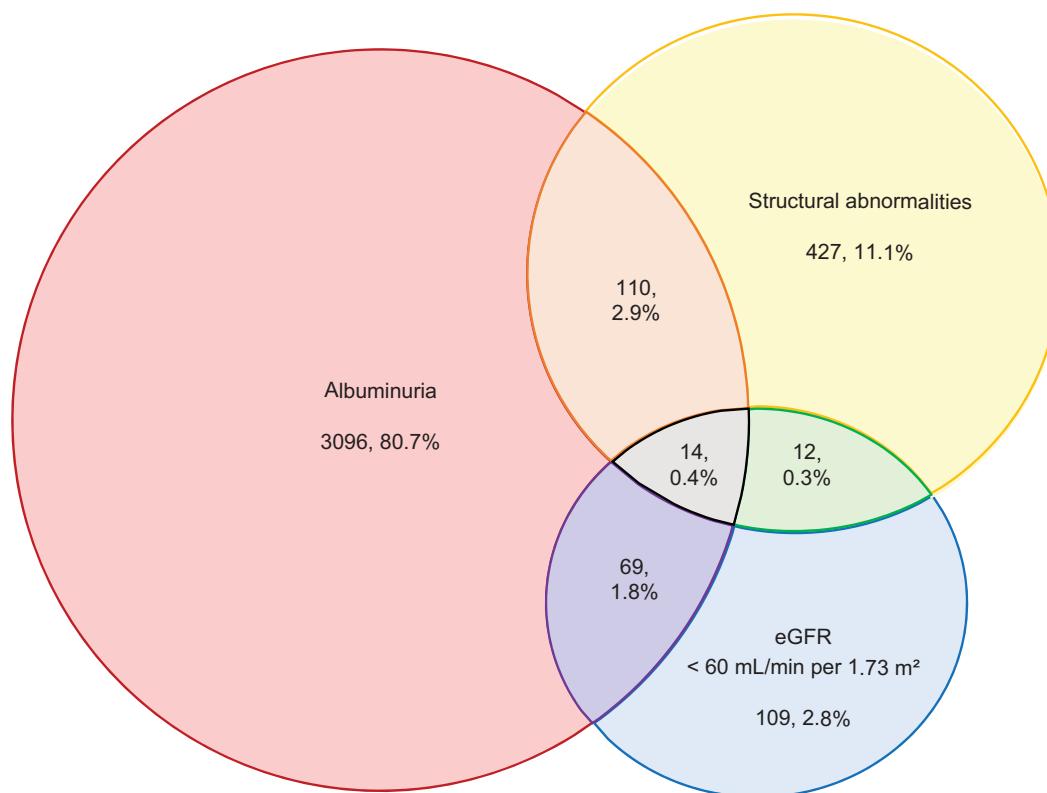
Case number detected by three kidney damage markers in 3837 chronic kidney disease patients. The red shape represents patients with albuminuria, which is defined as urine albumin creatine ratio ≥ 30 mg/g or ≥ 3 mg/mmol. The yellow represents patients with structural abnormalities detected by kidney ultrasound. The blue shape represents patients with decreased eGFR. The overlapping shapes represent patients detected by more than one kidney damage marker. The orange, green and purple shape represents patients detected by two diagnostic methods and the grey shape is by all three diagnostic methods. The percentage in each shape is calculated by dividing 3837 chronic kidney disease patients by case number in the corresponding shape.
